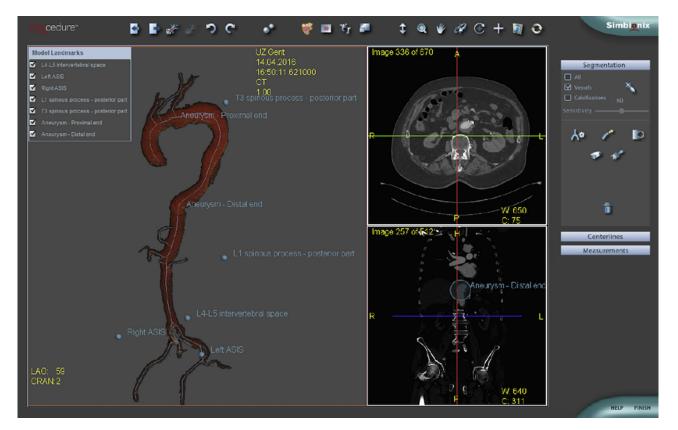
Construction of a virtual three-dimensional model with the PROcedure Rehearsal Studio (Simbionix USA Corp, Cleveland, OH) software. (ASIS = anterior superior iliac spine; CRAN = cranial; CT = computed tomography; LAO = left anterior oblique.)
